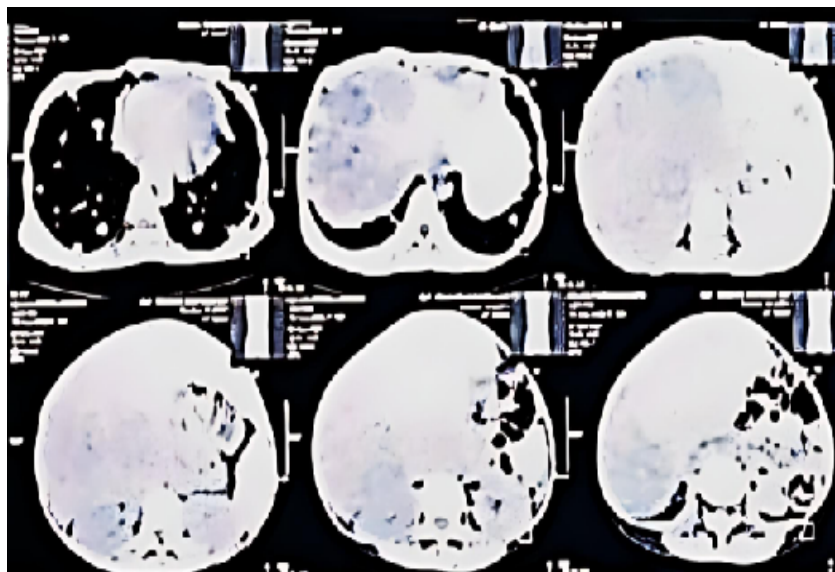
Multi Slice Computed Tomography (MSCT) scan of the abdomen revealed a liver enlargement with solid mass
